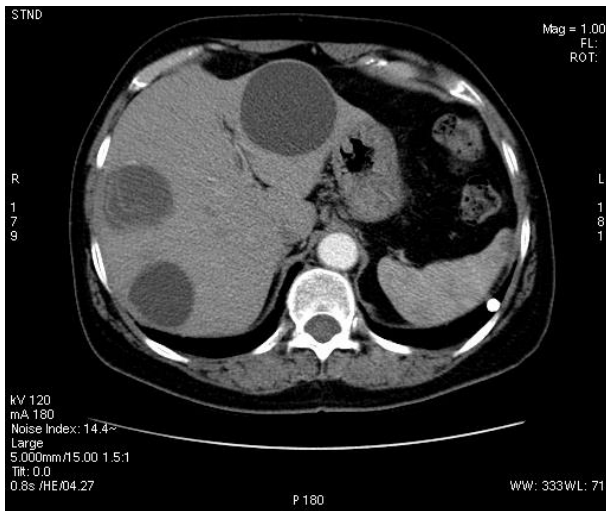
CT scan showing the cyst
